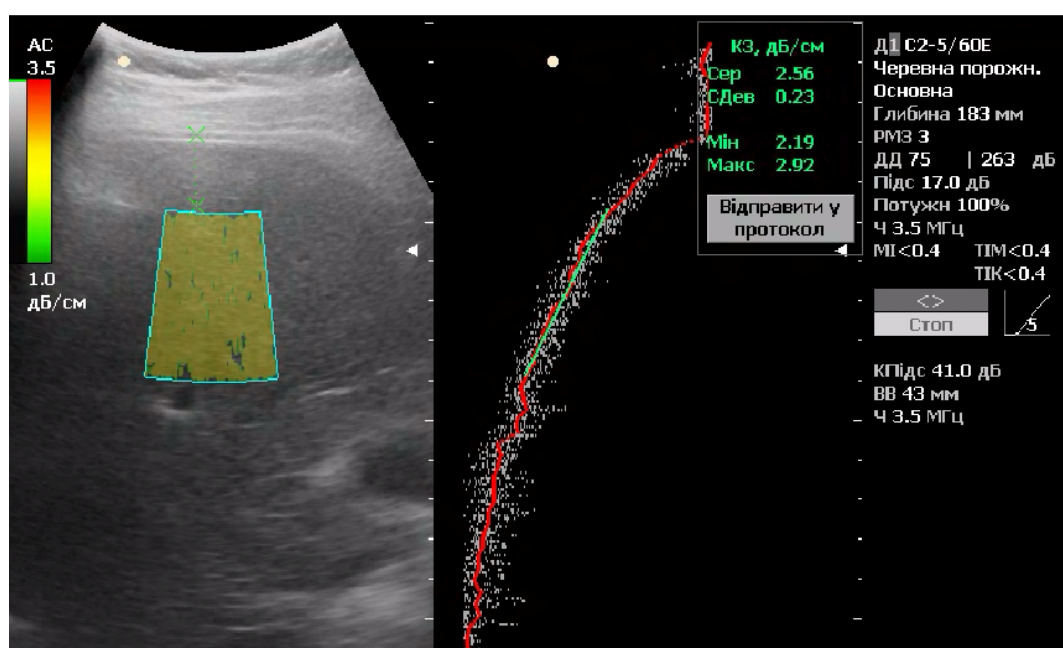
Quantitative ultrasound liver steatometry, stage S2 steatosis
